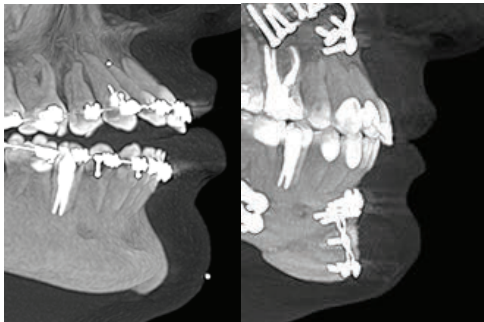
X-ray image before and after regulation of facial symmetry
